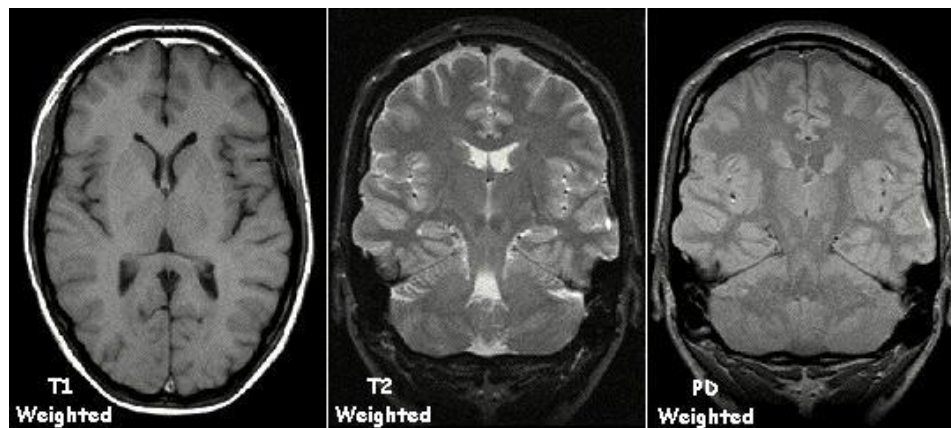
Brain images of T1-weighted, T2-weighted and PD-weighted.
